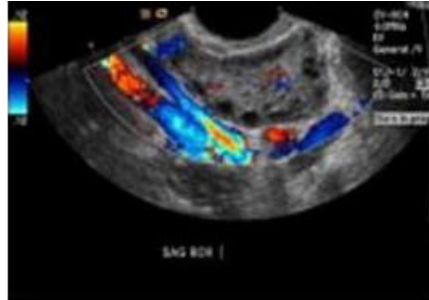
Transvaginal Ultrasound of 25 years old female (inability to conceive). Multiple (8-10) peripherally arranged small follicles in both ovaries.
